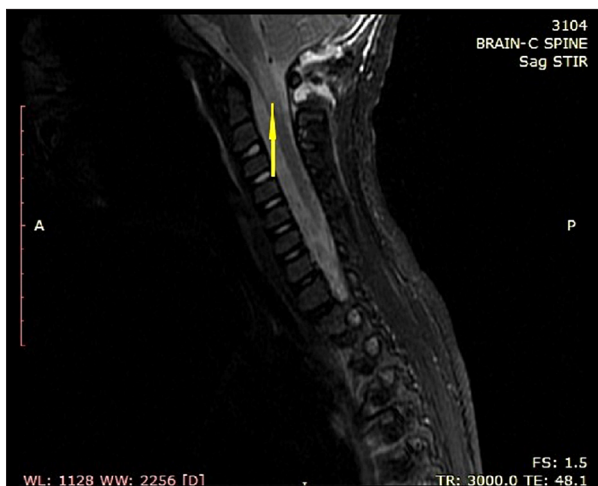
Post-operative magnetic resonance imaging (MRI), sagittal Short tau inversion recovery (STIR) sequence, depicting the infarction in the region of the cervico-medullary junction (yellow arrow).
